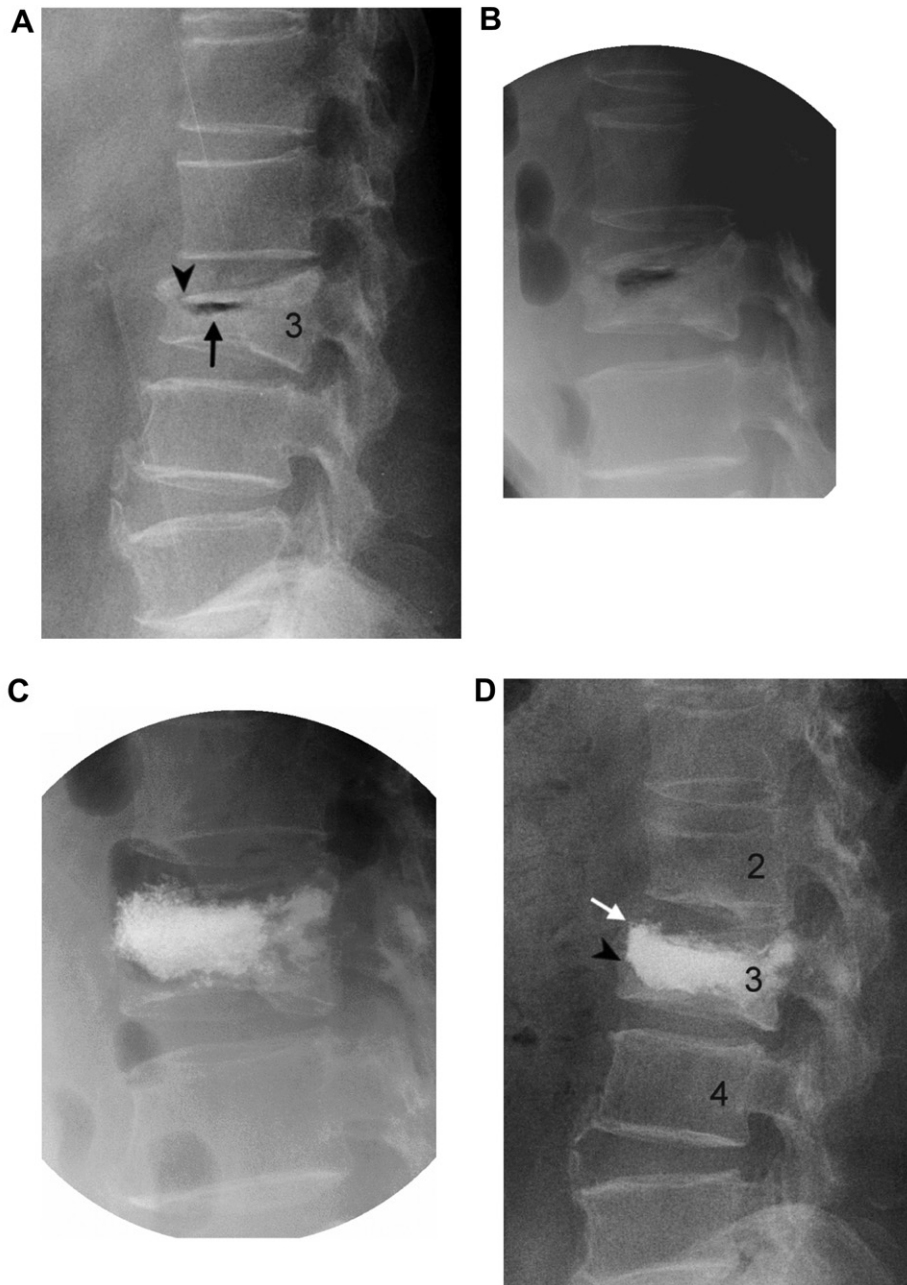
Percutaneous vertebroplasty was performed on one vertebral body (L3) in this case. (A) Pre-vertebroplasty plain radiograph shows avascular necrosis with a cavity (arrow) filled with gas inside the L3 vertebral body, and a disruption (arrowhead) in the superior endplate of this vertebral body. (B) Stored lateral view image at the angiography suite before puncturing of needle for vertebroplasty. No fracture is noted in the cranial and caudal adjacent vertebral bodies. (C) Stored lateral view image at the angiography suite right after vertebroplasty. No fracture is noted in the cranial and caudal adjacent vertebral bodies. The farthest extension of cement in the cranial end is disc level in the whole vertebral/disc column, and in the anterior third of the column. The farthest extension of cement in the caudal end is trabecular level. (D) Plain radiograph taken 2 months post-vertebroplasty shows new fracture with reduced height in the cranial adjacent vertebral body (L2). The cranial end of the L3 cement (white arrow) is in the disc level.
